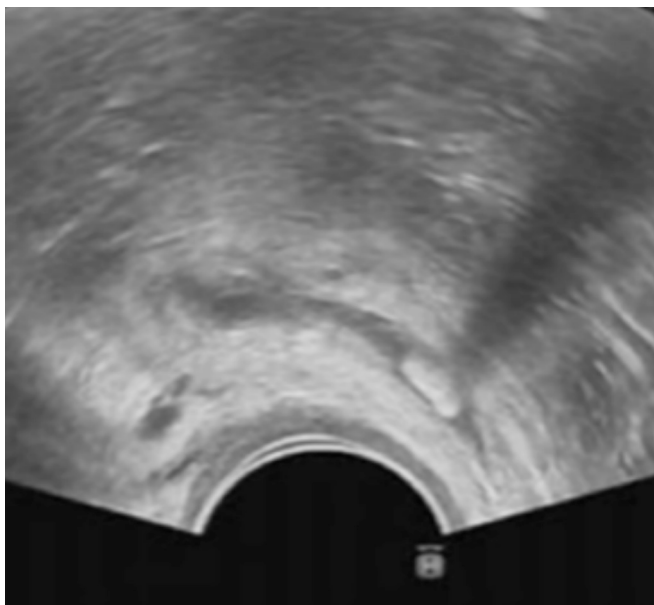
Transvaginal ultrasound showing the correct position of the hyperechogenic mesh-implant ventral and dorsal to the vaginal vault.
